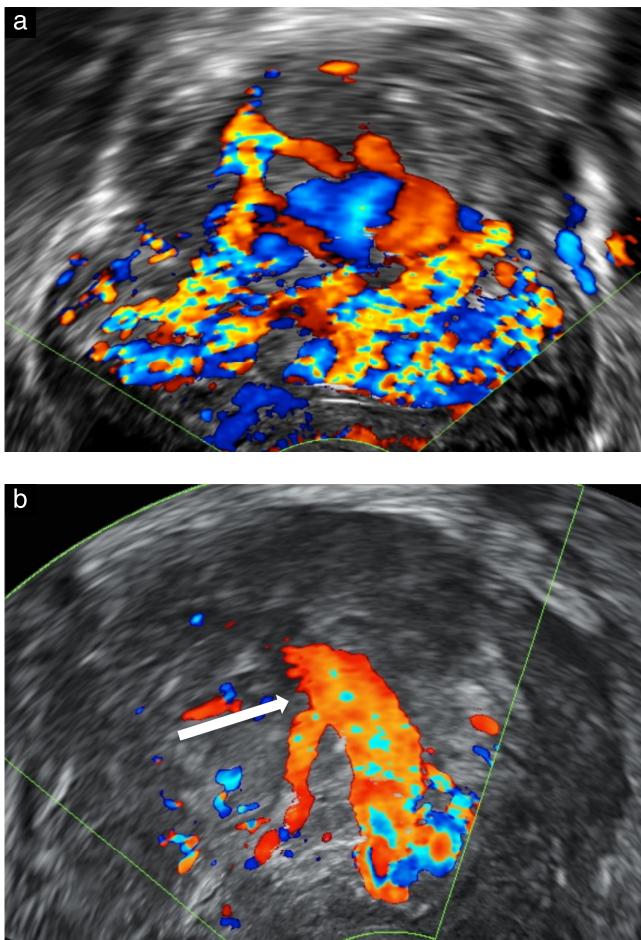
(a) Color Doppler image showing extremely vascular, thickened, irregular posterior uterine wall, in partial intramural pregnancy. No discrete trophoblast is discernible. (b) Color Doppler image showing single large blood vessel (arrow) delivering blood directly from uterine artery to retained pregnancy tissue in posterior myometrium, after patient had undergone uterine artery embolization prior to emergency surgery.
